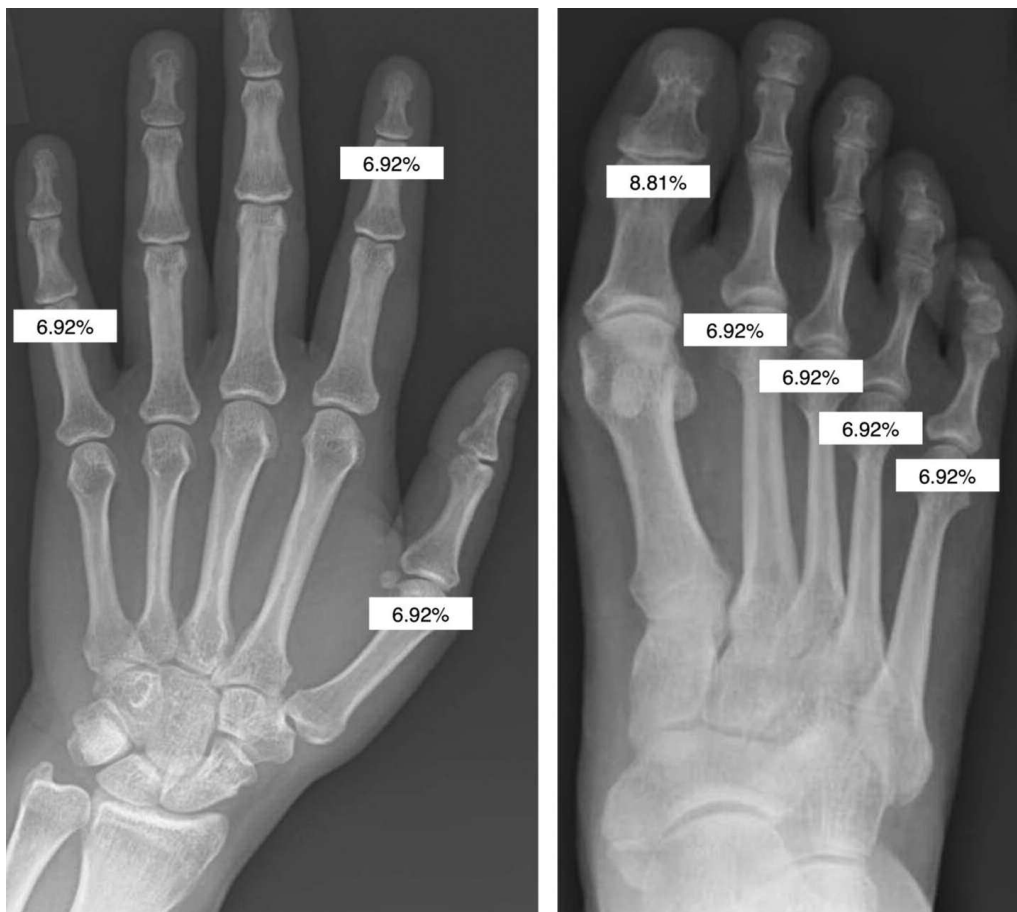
Eight joints most commonly affected by PAM at the most recent radiograph (frequency in percentages). PAM: psoriatic arthritis mutilans.
